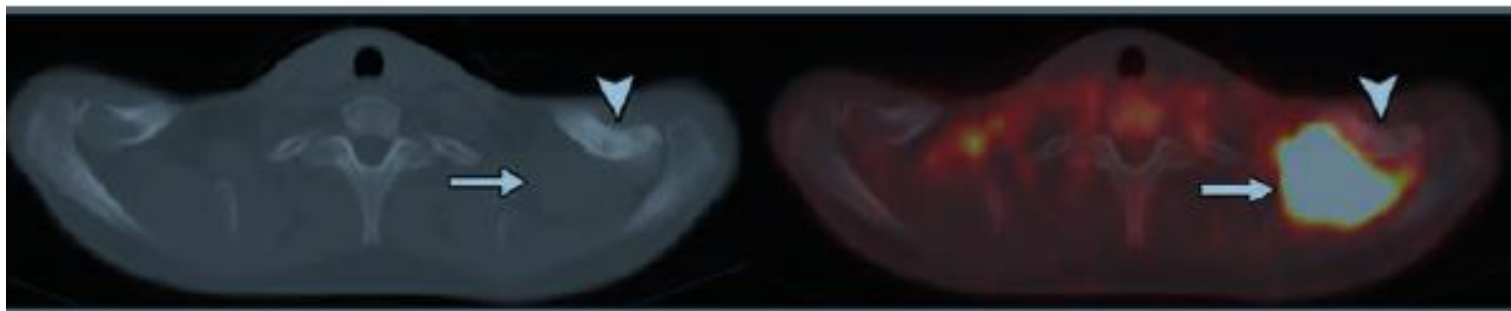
32-year-old man with Ewing sarcoma (ES) with bone metastases detected on 18F-FDG PET/CT but not bone scan.
